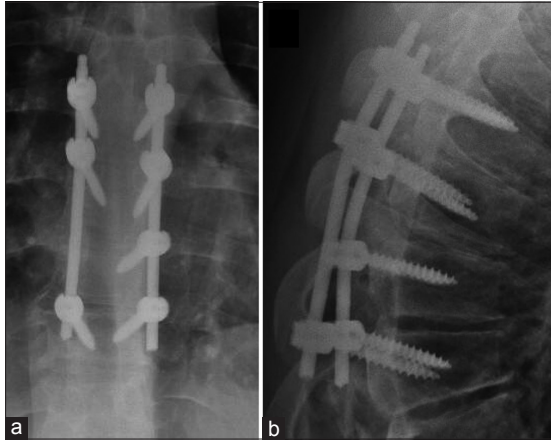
(a) Postoperative anteroposterior and lateral thoracic X-rays demonstrating a short T6-T9 fusion construct. (b) Postoperative lateral X-rays of the thoracic spine demonstrating short fusion of the thoracic spine.
